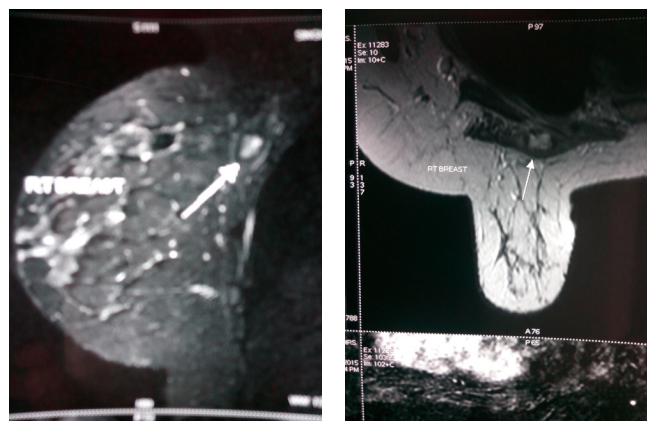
Site of larva of sparganum in MRI breast.
